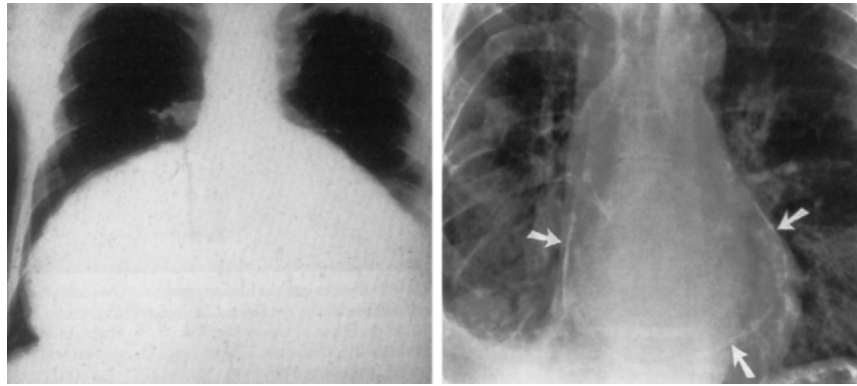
■ Chest radiographs in a patient with a very large pericardial effusion—“water bottle” sign (*left*)—and in a patient with constrictive pericarditis and pericardial calcifications (*white arrows, right*).
